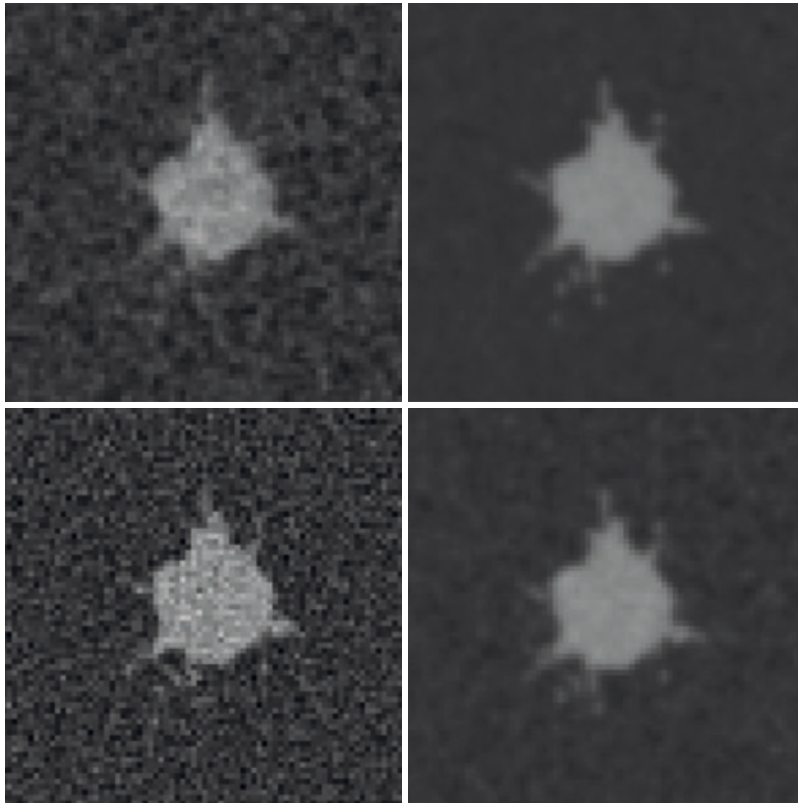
The same lesion model presented with different noise and resolution properties of commercial CT scanners
